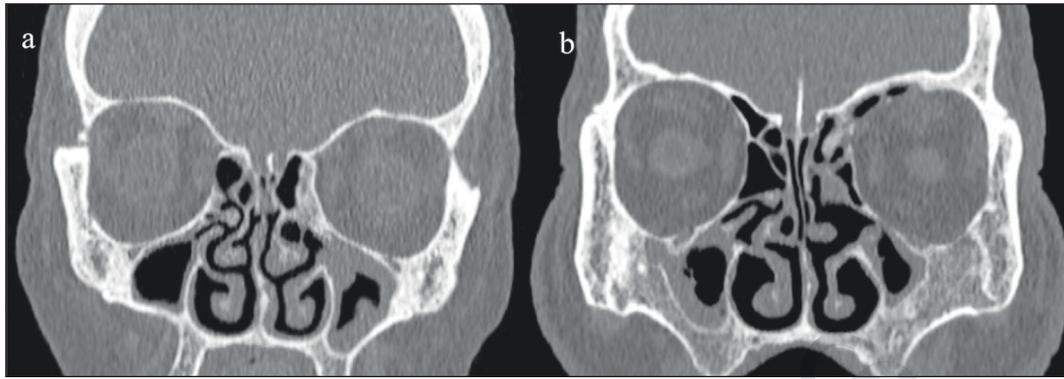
Coronal CT images demonstrating MSH. (a) Type 1 hypoplasia: mild reduction in sinus pneumatization with a normal uncinete process and open infundibulum; (b) Type 2 hypoplasia: moderate reduction in pneumatization with a hypoplastic or aplastic uncinete process and obstructed infundibulum
